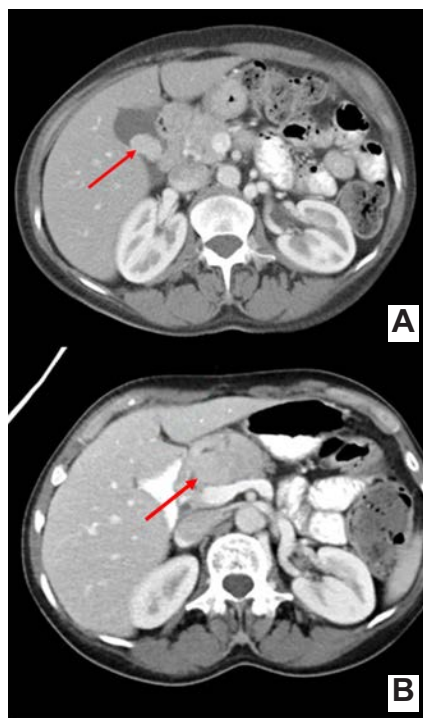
Abdomen computed tomography demonstrated gallbladder lesion. A) Initial lesion size; B) lesion size after 6 months.
